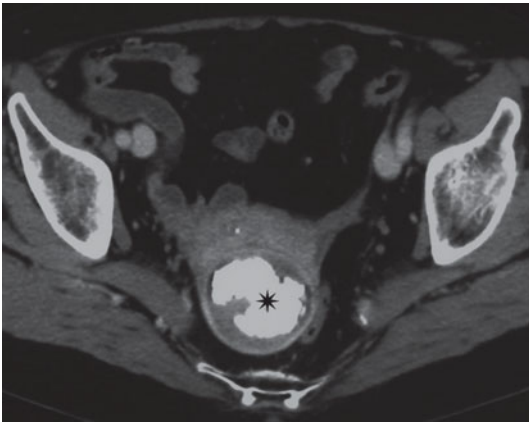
Computed tomography. Calcified leiomyoma. Axial image acquired in the venous phase shows an upright uterus and large heterogeneous leiomyoma with extensive central calcified component (*asterisk*)
